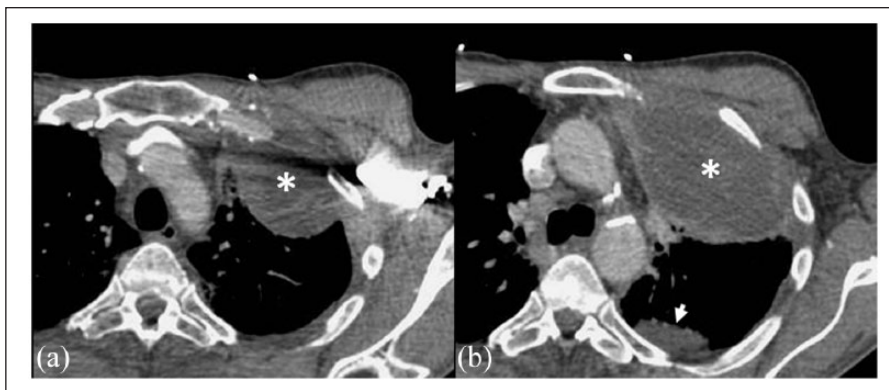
CT chest with contrast, post two cycles of AIM. (a) Superior aortic arch. (b) Carina.
